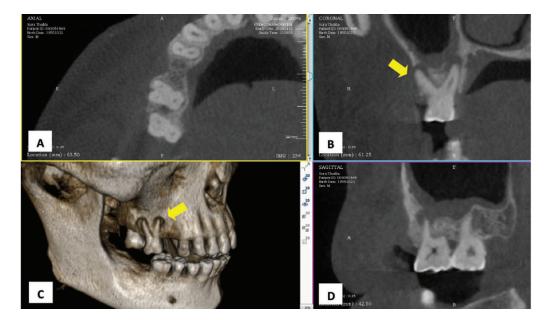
CBCT of case 9. (A) axial view, (B) coronal view, (C) reconstruction view and (D) sagittal view.
